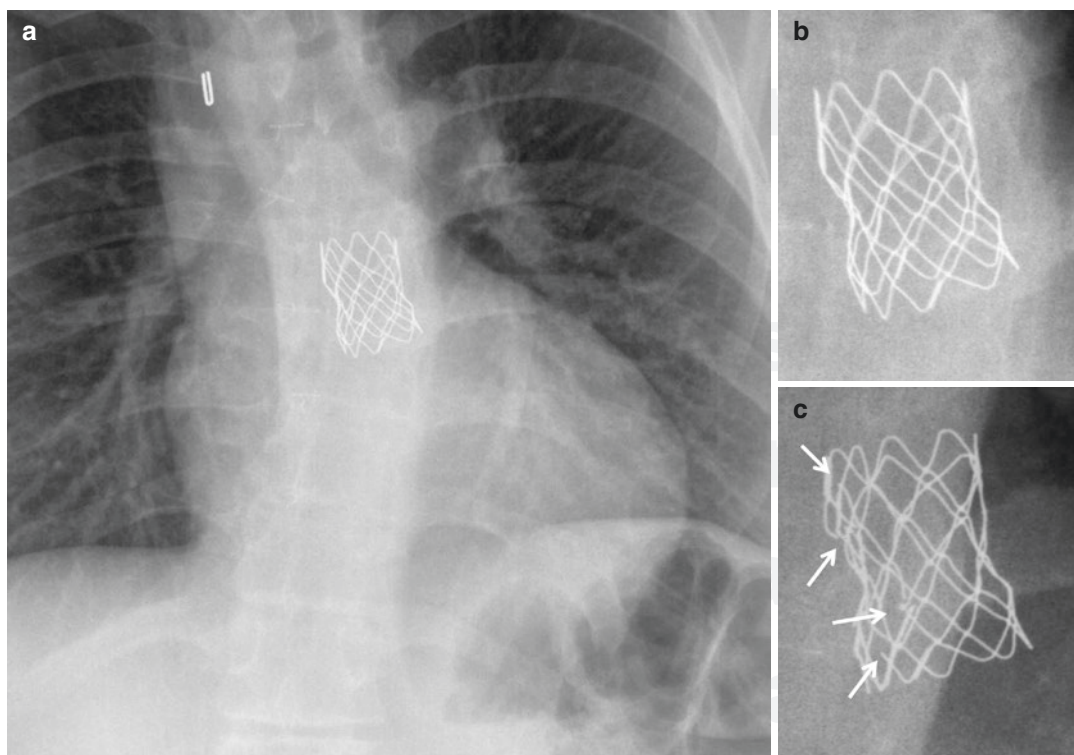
Twelve-year-old female patient with corrected TOF after pulmonary valve replacement with a valve-containing stent graft. Frontal chest X-ray (a) and detailed views (b, c). Suboptimal deployment of the stent graft
